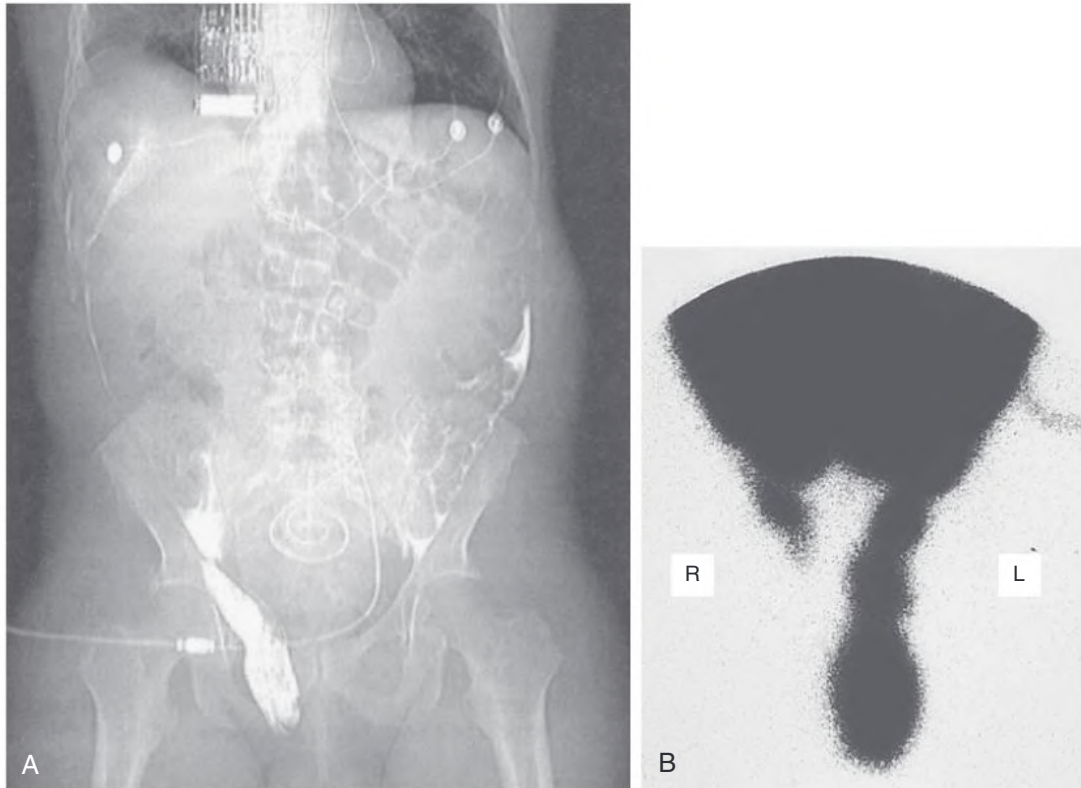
Inguinal Hernia During Peritoneal Dialysis. (A) Computed tomography scan after intraperitoneal injection of contrast material in a male patient showing dialysate flowing into a right inguinal hernia. (B) Peritoneal scintigram of a male patient on peritoneal dialysis showing bilateral inguinal hernias. The left hernia extends into the scrotum; the right hernia is less extensive. (From Tintillier M, Coche E, Malaise J, et al. Peritoneal dialysis and an inguinal hernia. *Lancet*. 2003;362:1893.)
